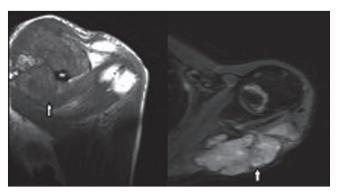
Tumoral lesion located in the infraspinatus muscle, as seen on these coronal T1-weighted and axial fat-suppressed T1-weighted sequences (arrows)
